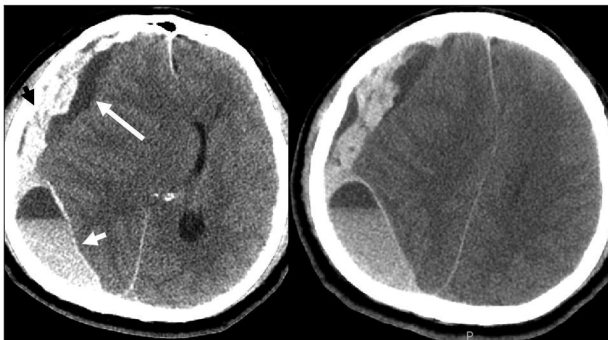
CT scans of case 2. Three different hematomas are corresponding to the episodes of head injuries on 49 days (short white arrow) prior to admission (PTA), on 9 days (long white arrow) PTA, and on the day of admission (black arrow).
